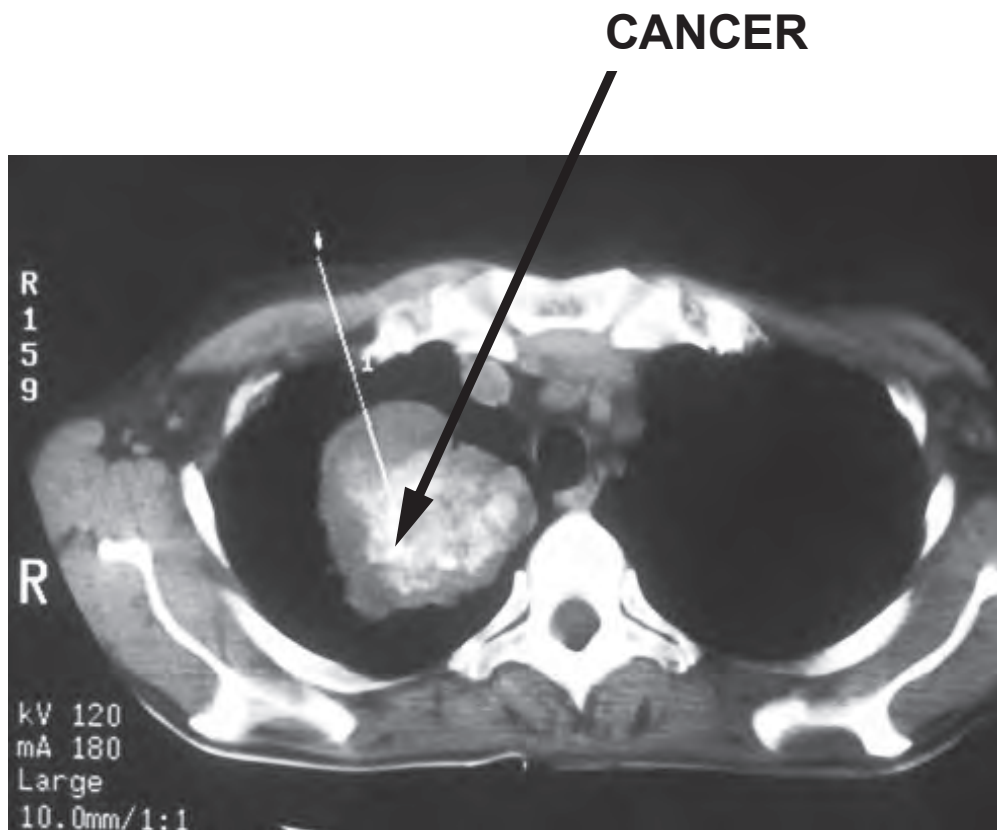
CHEST X-RAY OF PERSON WITH LUNG
